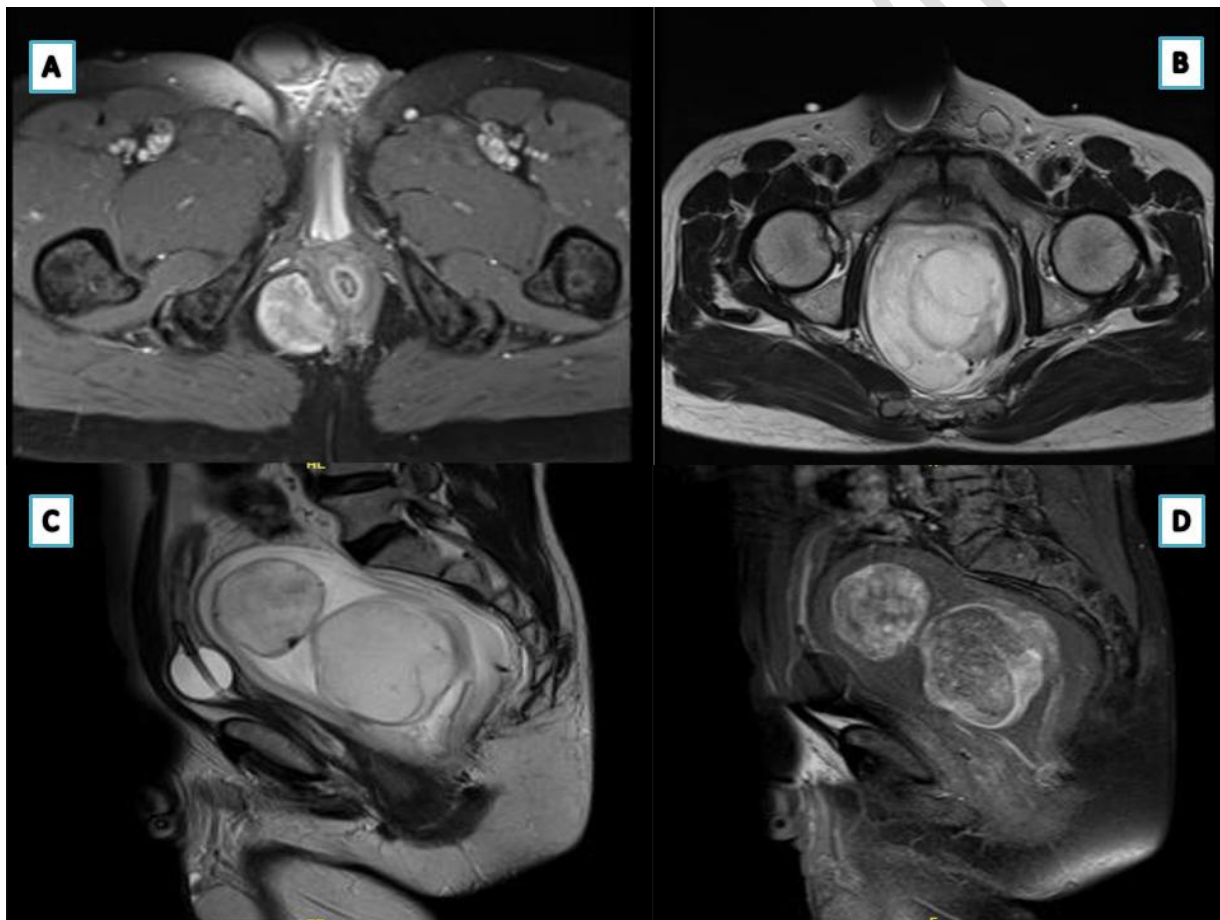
MRI pelvis: [A] cystic lesion originating from the posterior lateral part of the rectum. [B] Large cystic lesion compressing the rectum. [C, D] The sagittal section shows a large cystic lesion with 2 daughter cysts seen within the cyst, compressing the urinary bladder anteriorly.
